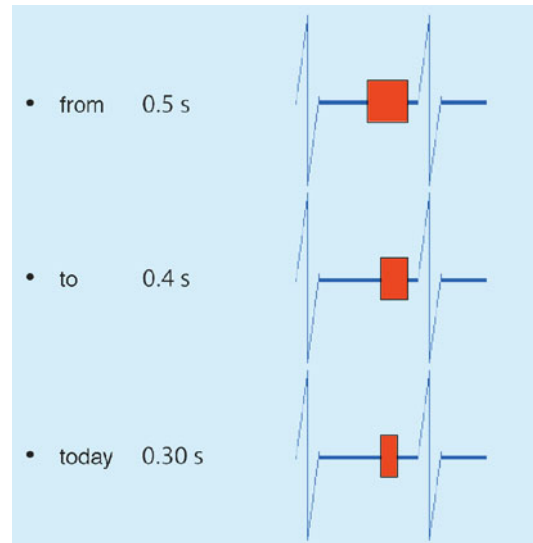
Rotation time of the X-ray tube: during cardiac-gated image acquisition. The width of the red area in telediastole represents the imaging window (time) for data acquisition: the shorter the acquisition time, the fewer the motion artifacts
